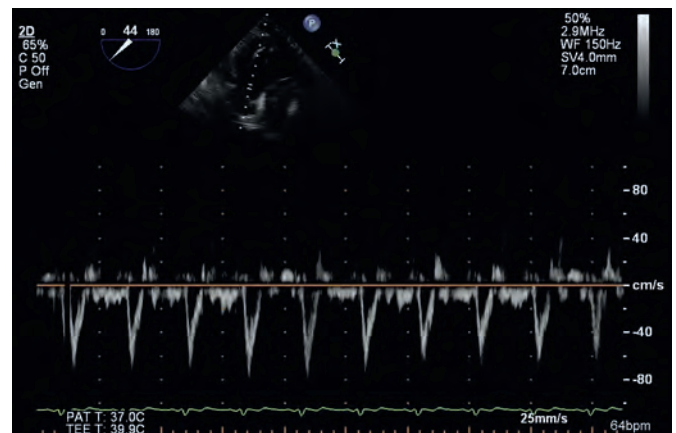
Deep transgastric echocardiographic view with the pulsed-wave Doppler probe placed in the left ventricular outflow tract. The respiratory changes seen in the peak velocities indicate fluid responsiveness.
